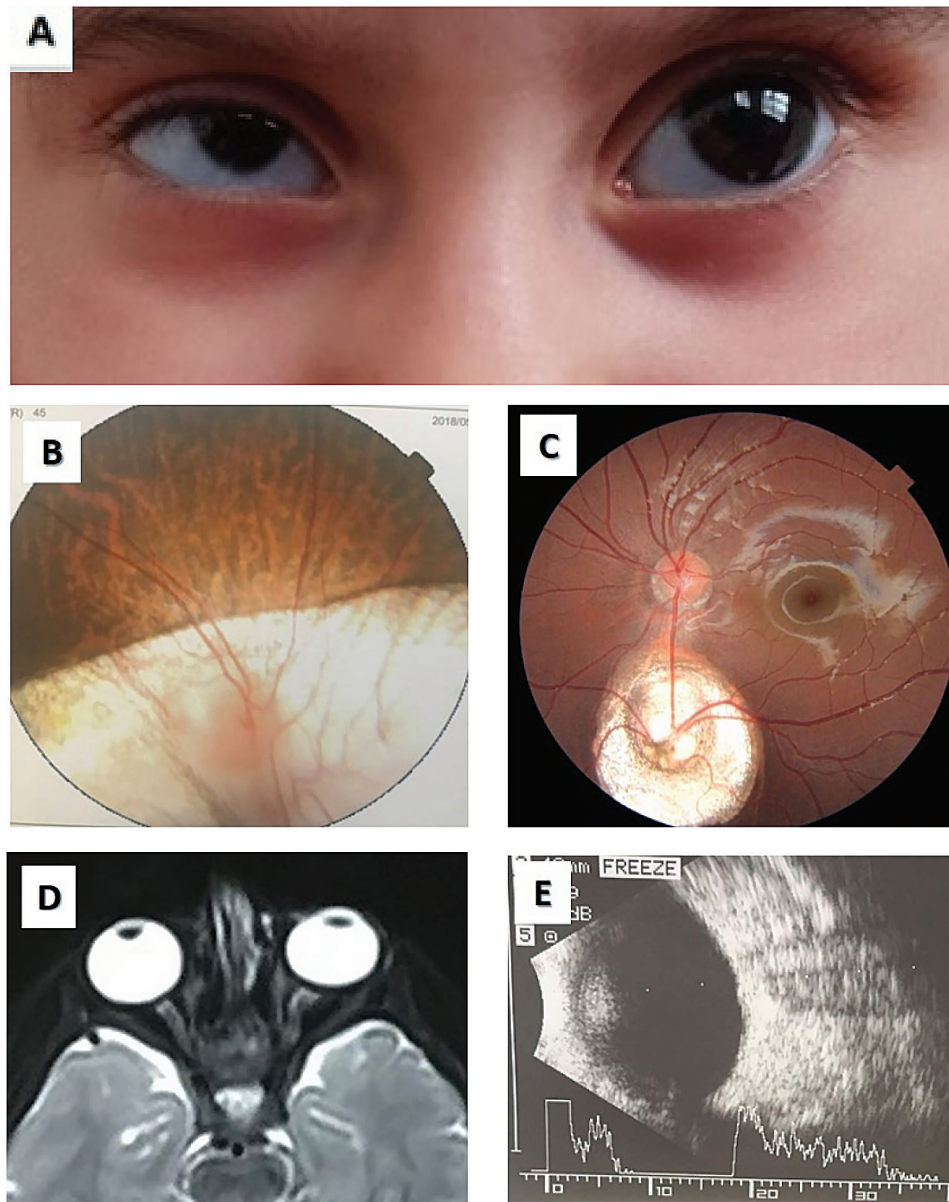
(A-E): In the external eye examination (A), the right eyelid fissure and the eye itself appeared smaller than the left side. Fundoscopy (B) revealed a large chorioretinal coloboma involving the macula and optic disc in the right eye. In the left eye (C), a disc-like structure was observed inferiorly and slightly nasally to the actual optic disc. Orbital and brain MRI scans (D) were unremarkable, confirming the presence of a single optic nerve in each eye. B-scan imaging (E) demonstrated only one optic nerve stalk in the left eye
